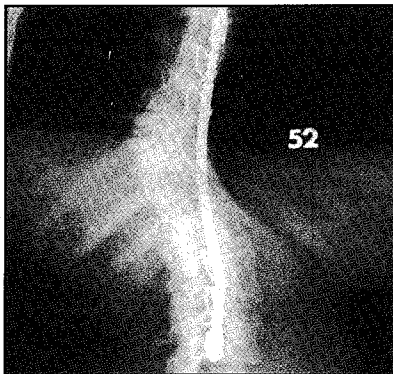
A-P radiograph at maturity at 17 years and 10 months showing further correction of coronal curve to 52 degrees.
